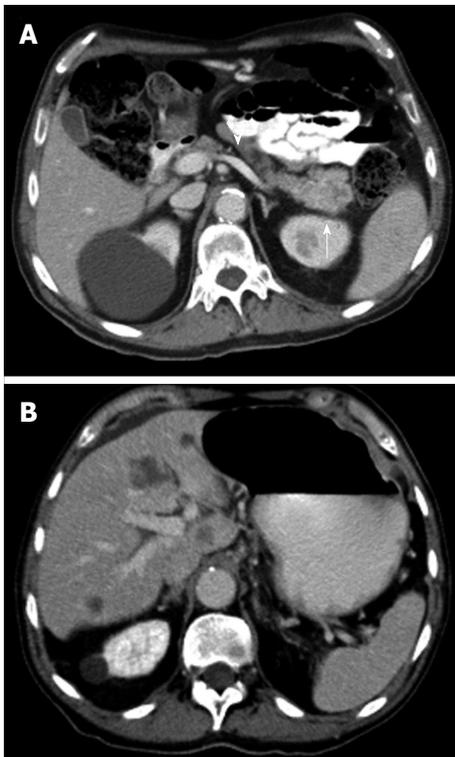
Contrast enhanced multidetector computed tomography image. A: In portal venous phase depicts a mass (arrow) in the pancreatic tail with permeability of the splenic vein (arrowhead); B: Focal round focal hypodensities with different sizes, localized in both hepatic lobules, represent metastatic spread to the liver. Pancreatic adenocarcinoma was proven by biopsy.
